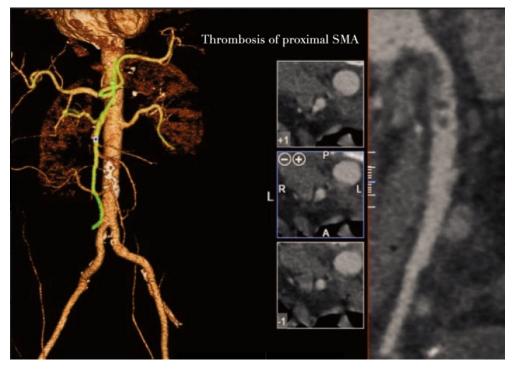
CT findings of thrombosis of SMA near the origin
